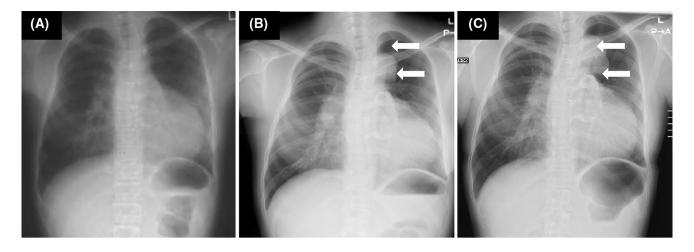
Chest X-ray (a) showed calcified outflow patch and cardiomegaly only when she was 14 years old, but an abnormal mass lesion (white arrows) in the left upper mediastinum was observed when she was 30 years old (b), and it increased when she was 32 years old (c)
